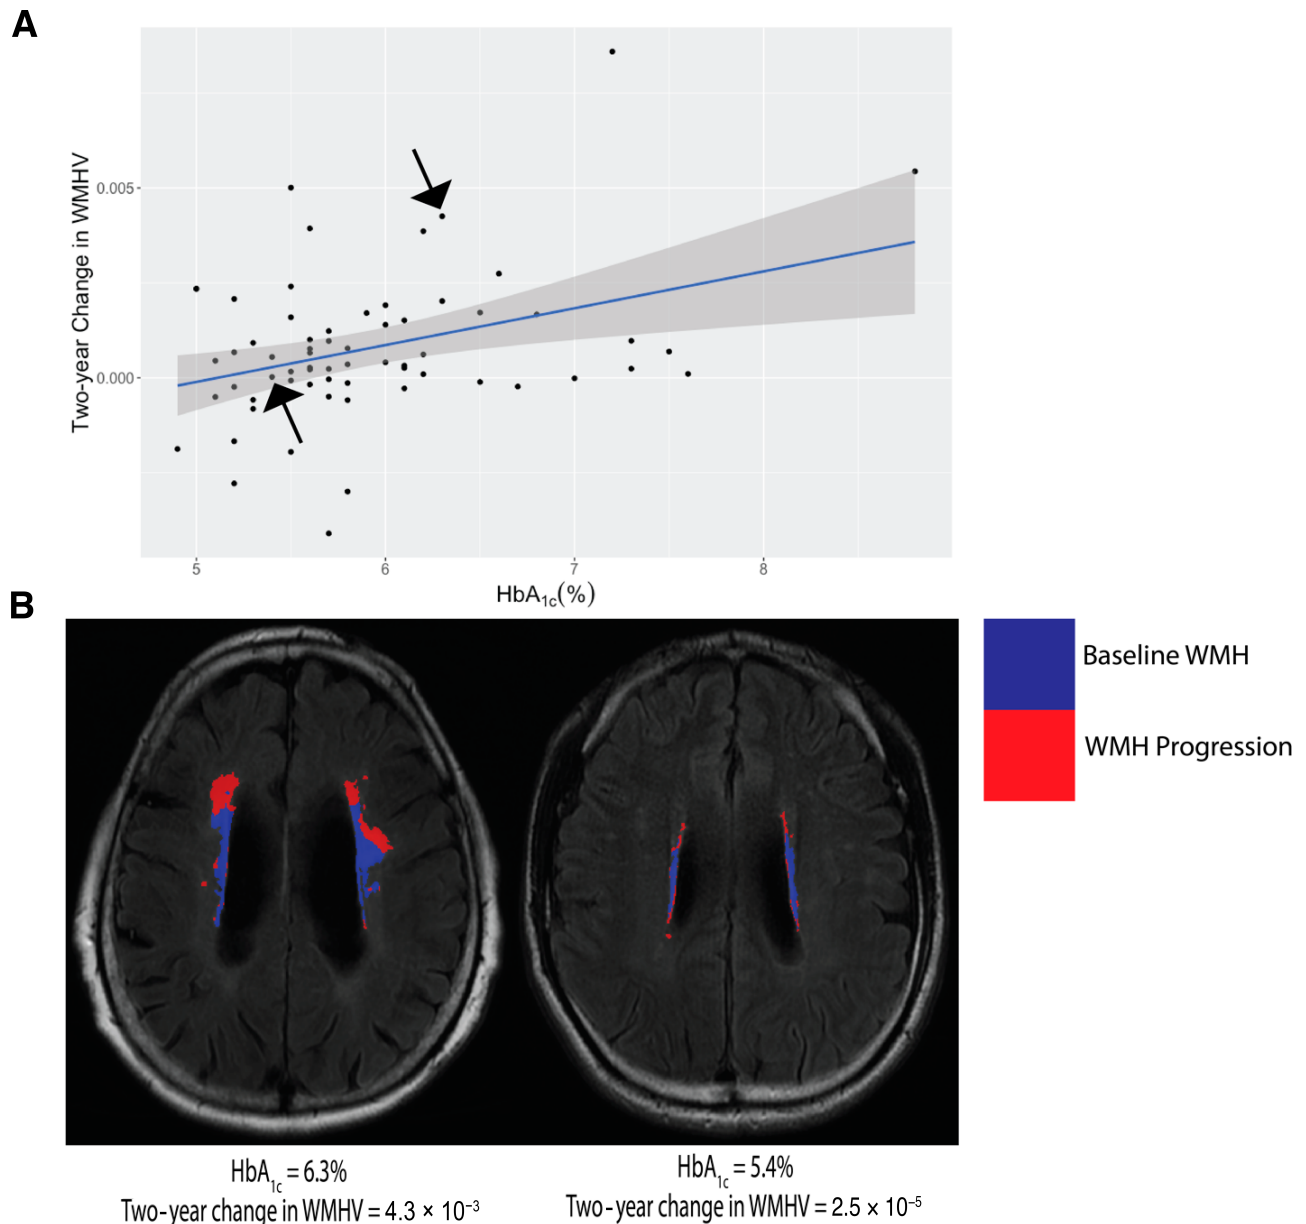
A: HbA_{1c} is significantly associated with 2-year WMHV progression. The two black arrows represent the two participants shown in (B). B: MRI scans of two individual participants. WMH from the first scan was registered and overlaid with the second scan and its WMH to display the WMH progression over 2 years. One participant had high HbA_{1c}, WMHV, and WMHV change; and the other had low HbA_{1c}, WMHV, and WMHV change. Shaded area represents the 95% CI.
